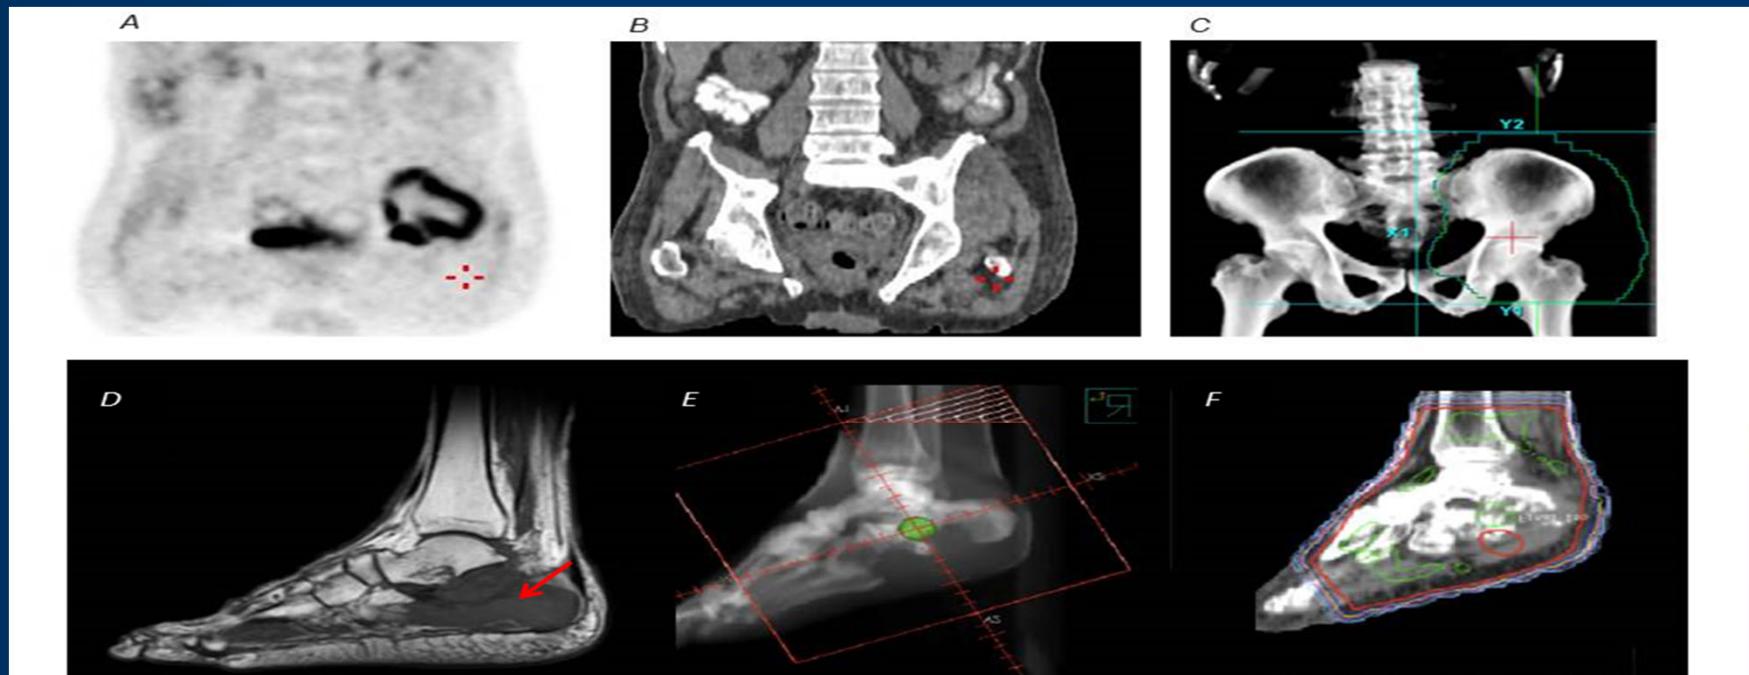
Radiation treatment field design. (A) Chloroma in the left pelvis on positron emission tomography and (D) coronal computed tomography imaging. (C) Radiation treatment field. (D) Chloroma in the calcaneus as seen on a T1 MRI (arrow). (E) Radiation treatment fields. (F) Dose distribution, red line represents 20 Gy isodose line.
